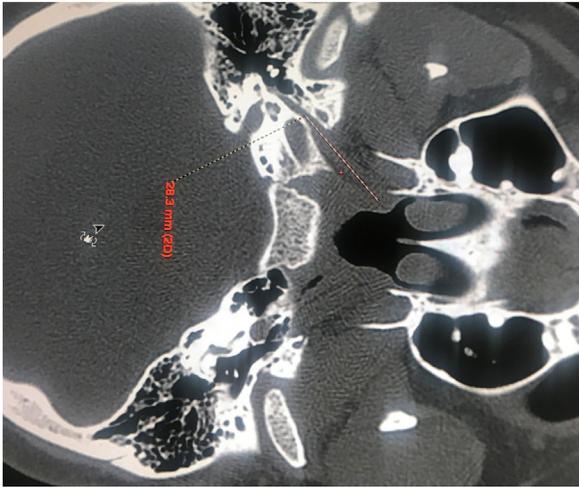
Computed tomographic image of the length of cartilaginous eustachian tube.
